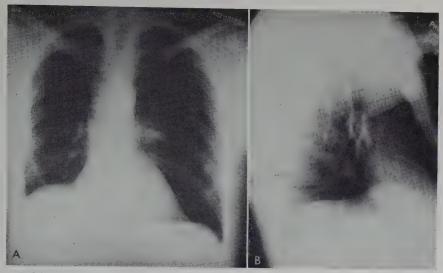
(Case II). Late postoperative anteroposterior and lateral roentgenograms of the chest demonstrate good healing and accommodation of the right upper lobe in the right hemithorax, without necessity for mediastinal shift.
